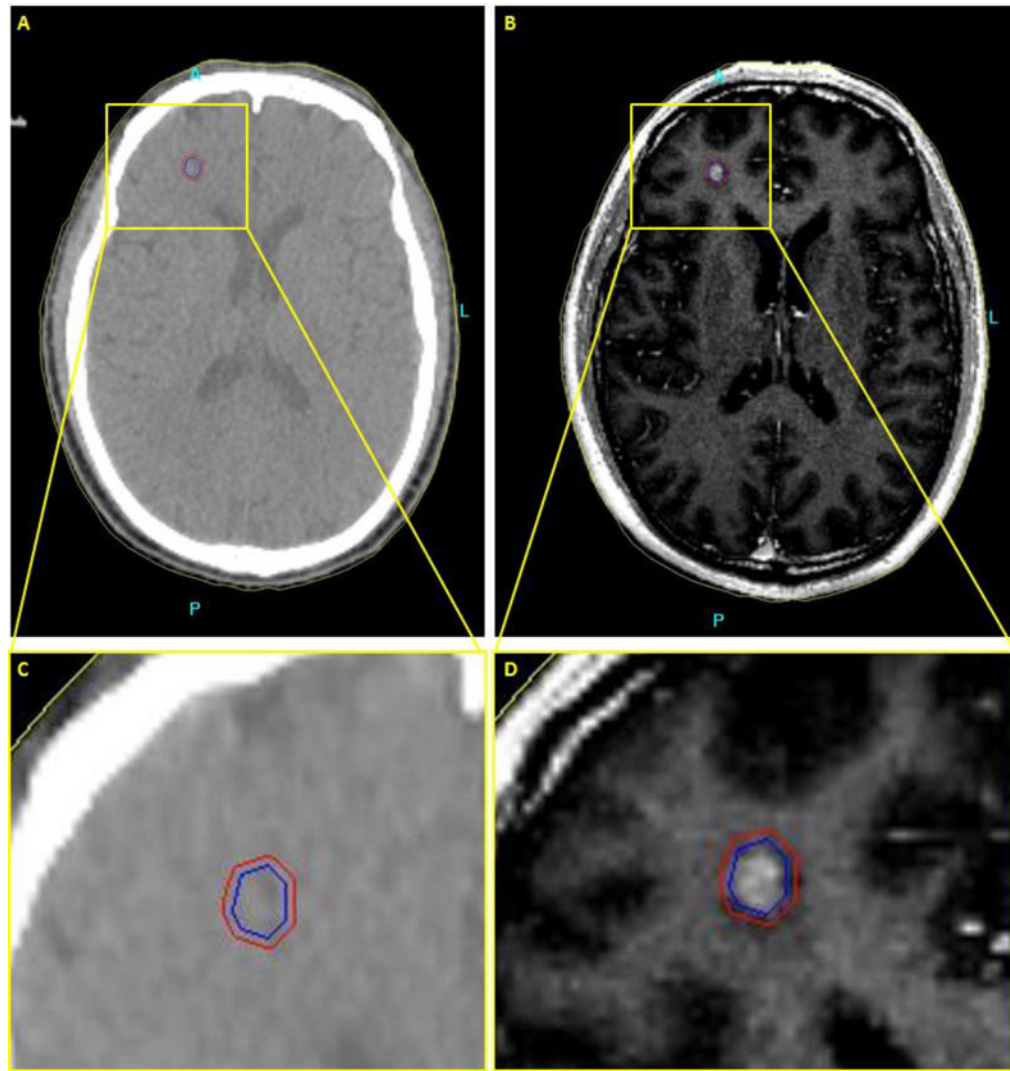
Axial brain images of patient with a metastatic tumor in the brain. (a,c) CT image. No contrast between the tumor and the surrounding normal tissue. (b,d) T2-weighted Fluid-attenuated inversion recovery image (FLAIR) MR image. Higher soft tissue contrast of the MR image leads to more accurate delineation of the tumor.
